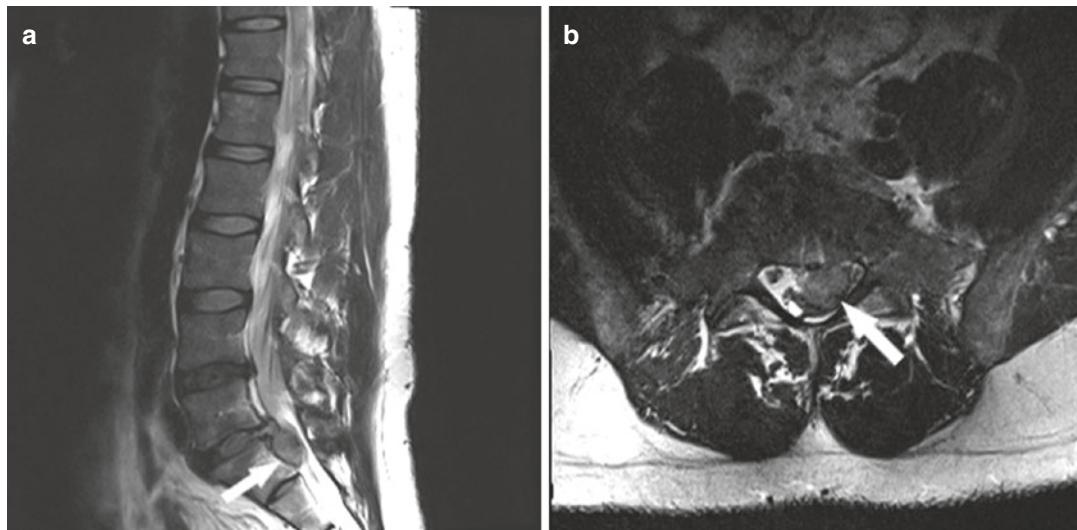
(a) T2 sagittal and (b) T2 axial MR images of the lumbar spine showing a herniated L5–S1 disc (white arrow) to the left causing significant nerve compression
